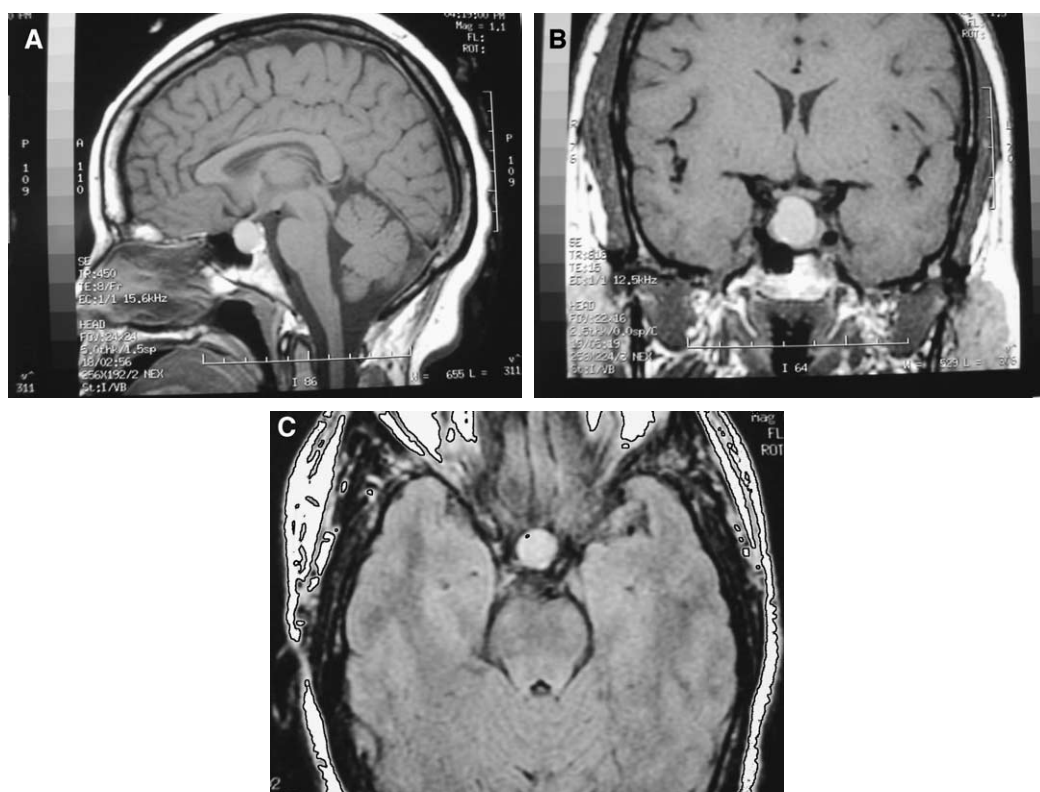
Rathke's cleft cyst. (A) Sagittal T1-weighted image shows a hyperintense mass in the sella with slight suprasellar extension. (B) Coronal T1-weighted image shows a hyperintense mass with suprasellar extension, which appears to encroach on the optic chiasm. (C) Axial T2-weighted image shows the mass to be hyperintense as well.
